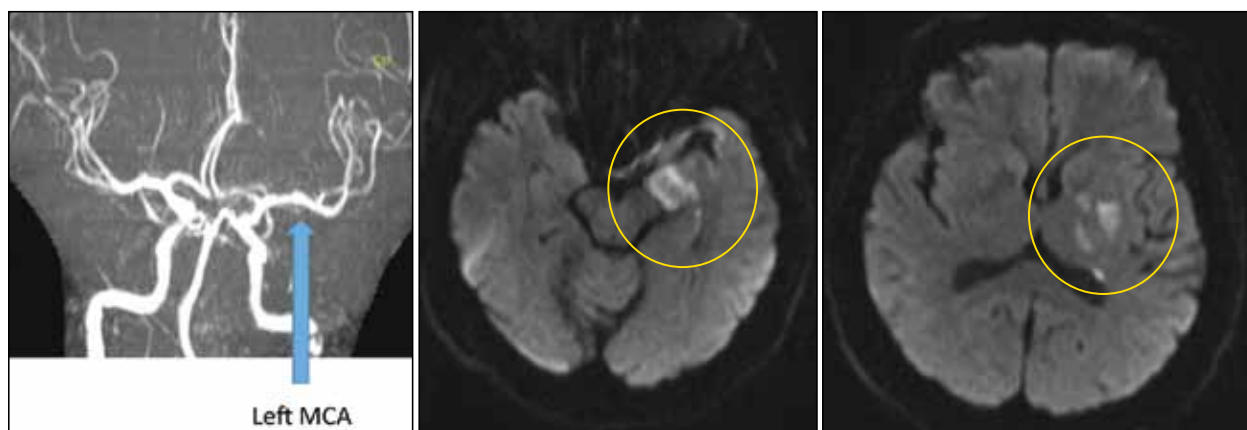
MRA of the intracranial circulation posttreatment day 1 after recanalization showing complete recanalization of the left MCA. Diffusion MRI images: areas of increased signal intensity are seen in the left temporal lobe and the left deep nuclei. Encircled stroke in the left MCA distribution.
